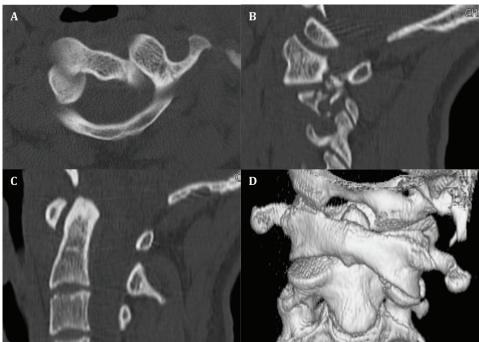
The computed tomography (CT) scan of the craniovertebral junction of the patients. The axial images reveal atlantoaxial rotatory subluxation (AARS) with left facet locked (A); the sagittal images through the left C1-C2 facet joint (B) and mid-sagittal views (C) clearly demonstrate the AARS with left locked facet. The coronal 3D reconstruction images reveal rotation of the C1 about 40 degrees relative to C2 (D).
